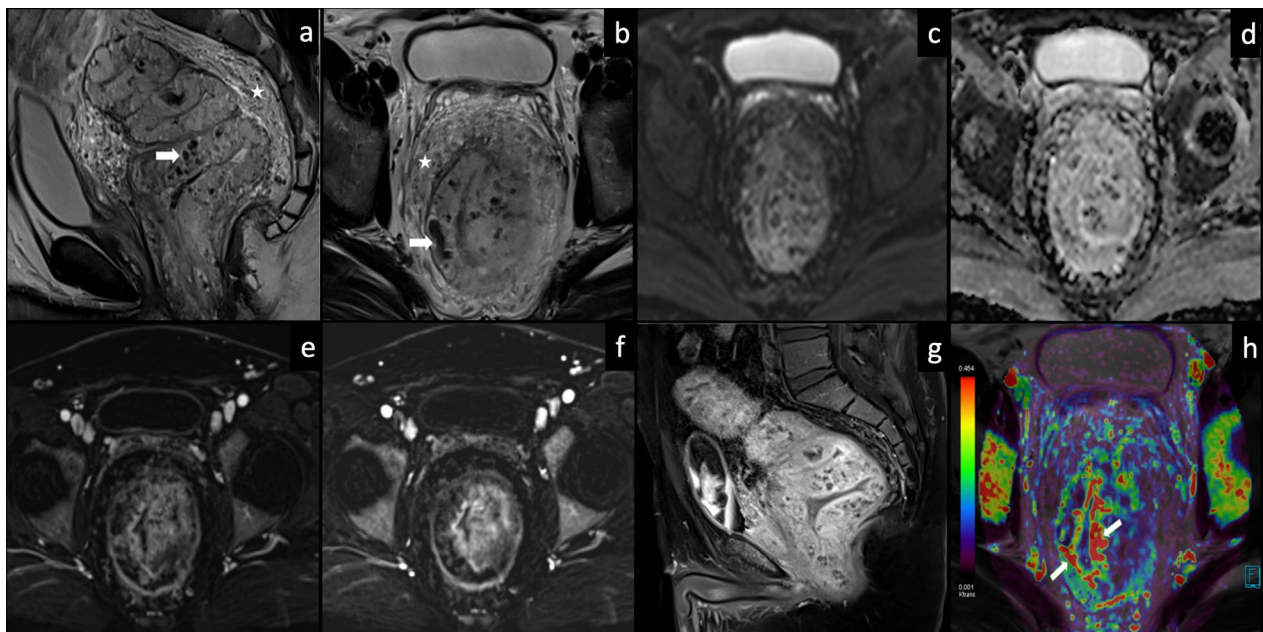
The sagittal (a) and axial (b) T2W MR images show diffuse thickening in the wall of the rectosigmoid colon characterized by increased signal intensity. The hypointense serpiginous areas represent dilated tortuous venous structures (thick arrows), and multiple round hypointense foci represent phleboliths. The mesorectal fascia has increased heterogenous signal intensity (asterisk). The lesion does not show diffusion-restriction on DWI (c) and ADC map (d). The lesion does not show prominent early or late contrast enhancement on the axial dynamic contrast-enhanced T1W images (e, f). However, the sagittal delayed contrast enhancement image (g) reveals that the lesion has heterogenous diffuse contrast enhancement (g). Overall, the lesion shows decreased perfusion (e) interspersed with highly perfused areas consistent with the dilated venous structures (arrows) (h)
